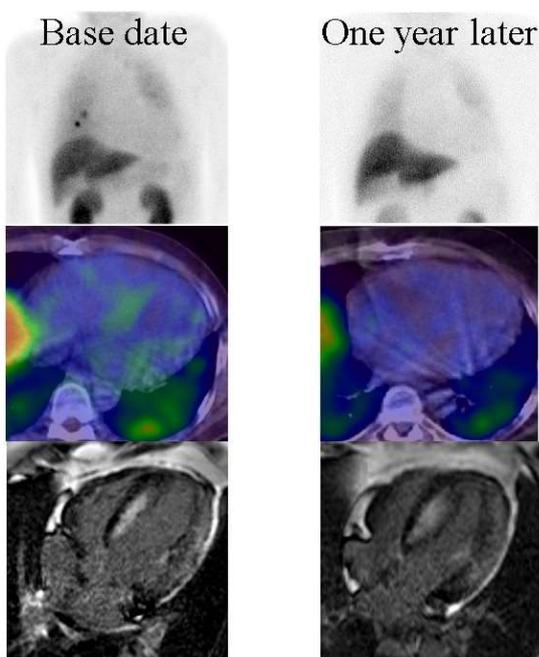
Cardiac scintigraphy and CMR of a patient (No. 7) with cardiac hypertrophy, but was not diagnosed with amyloidosis.
